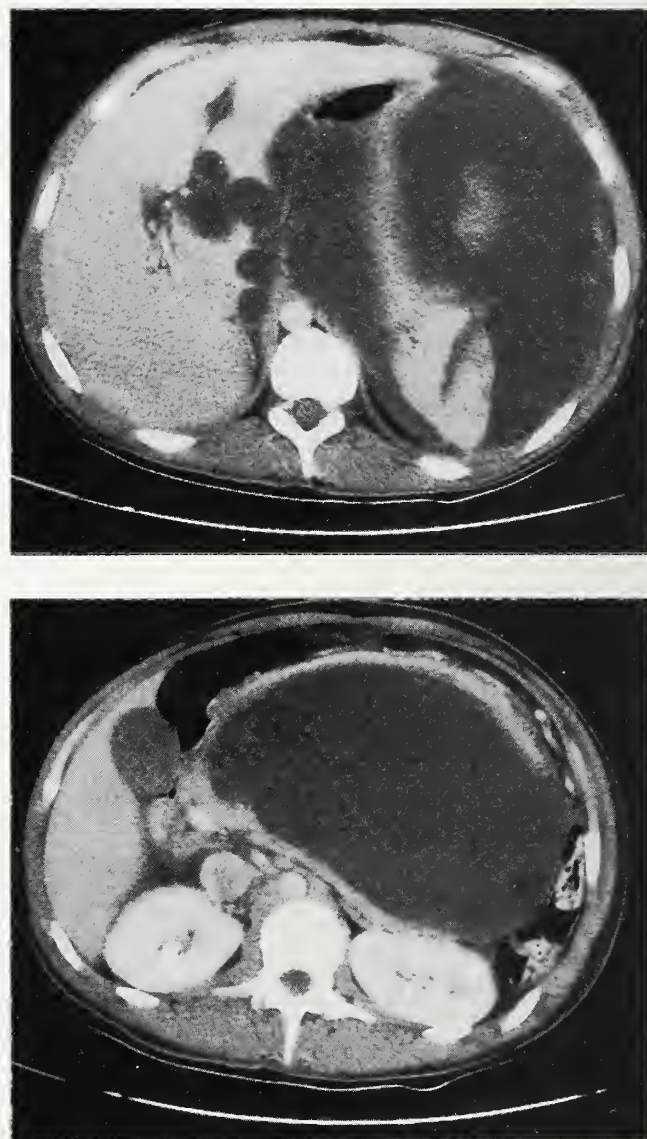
(Top) Double contrast enhanced CT scan of the upper abdomen in the region of the spleen demonstrating a large splenic pseudocyst. (Bottom) Image from the same CT scan demonstrating compression of the left kidney and displacement of abdominal contents.
